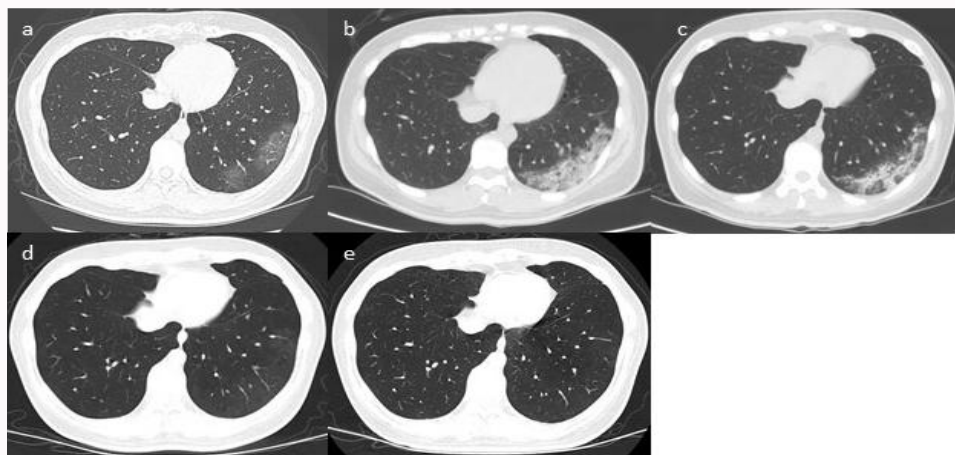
Chest CT images of the 31-year-old woman.
